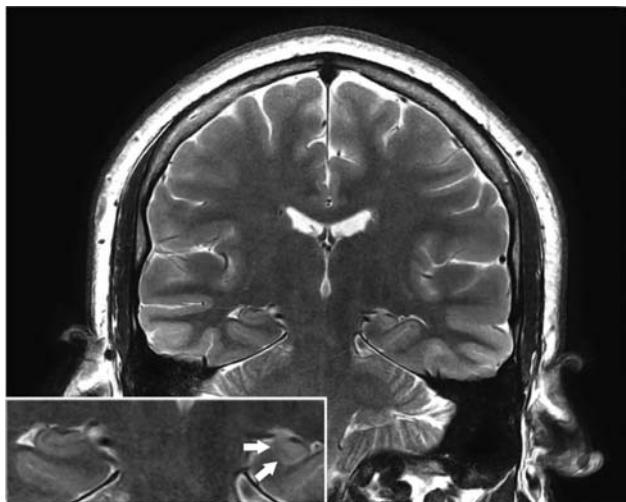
A magnetic resonance imaging (MRI) coronal section through the temporal lobes of an adult with severe, long-standing epilepsy. Note the marked, unilateral atrophy of the hippocampus (arrows) in the epileptic patient.
